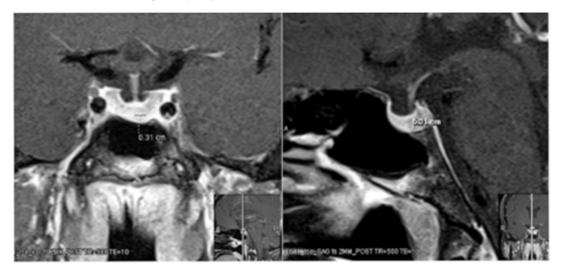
Figure I Enhanced MRI of the Pituitary showing a 3 mm Pituitary Adenoma.
